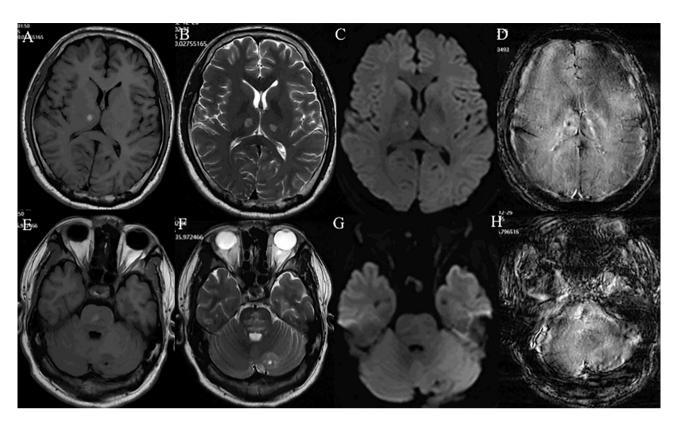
Patient 2 Acute necrotizing encephalopathy in a 23-year-old male presenting with mental disorders. Axial T2-weighted (B and F) and T2 FLAIR (C and G) images show hyperintensities in the bilateral thalami and pons. Axial T1-weighted image (A and E) reveals hyperintensities, suggesting haemorrhages in the right thalami and pons. D and H SWI image demonstrating cerebral microbleeds in the right thalamus
